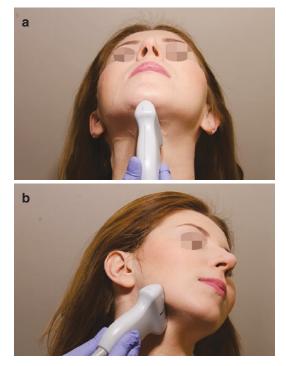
Patient positioning for head and neck ultrasound. (a) Head tilted backwards. (b) Head turned away from the scanned side
